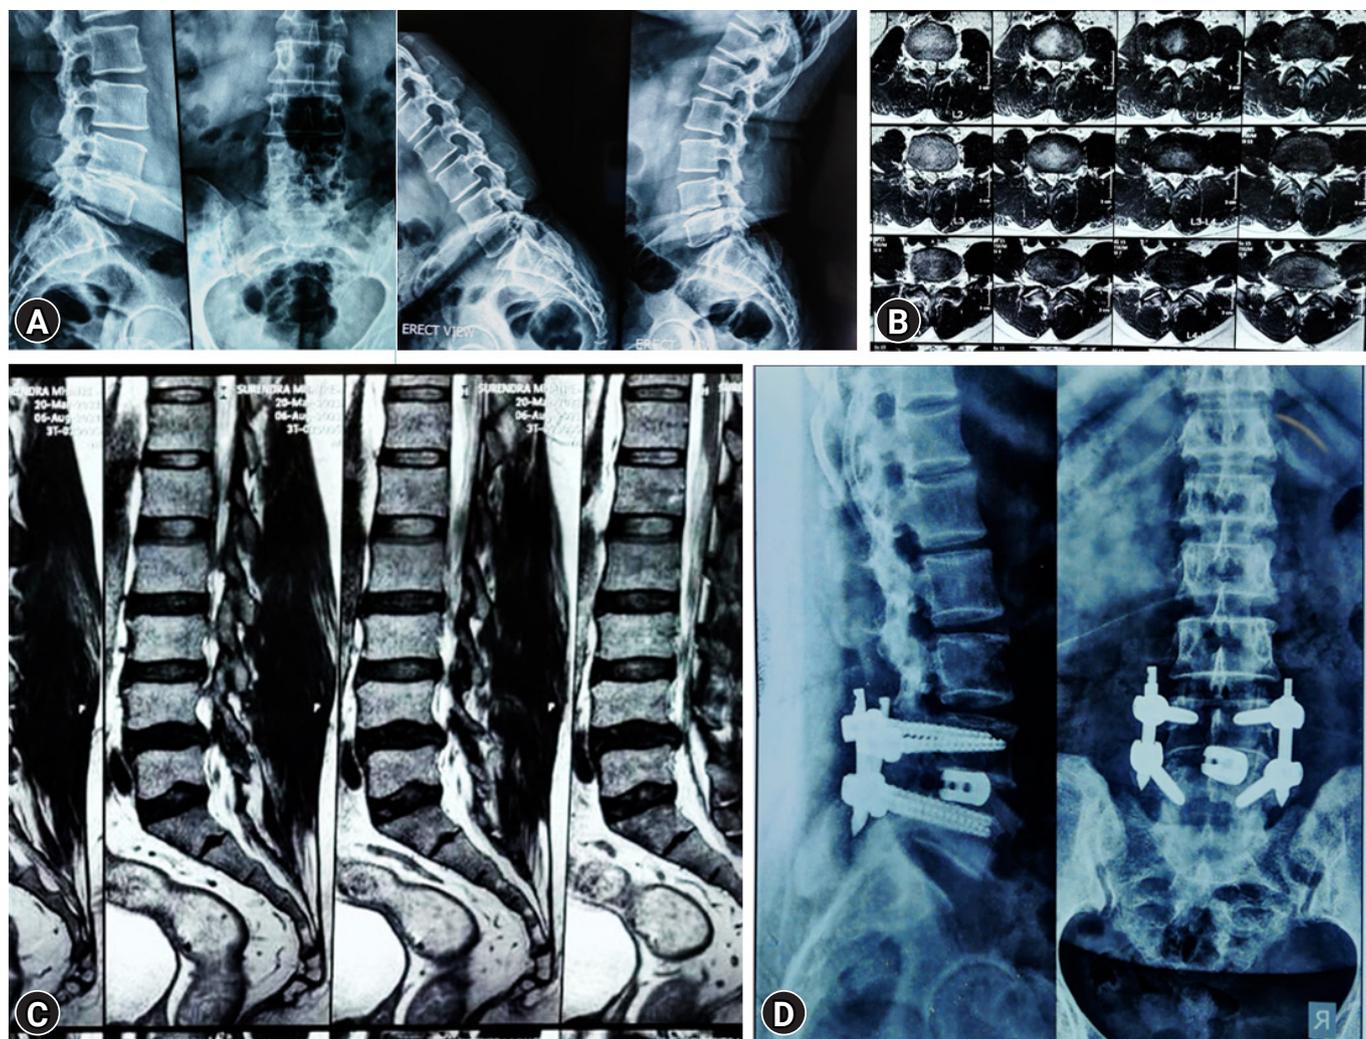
Index case. (A) Pre-operative plain radiographs. (B) Axial MR images. (C) Sagittal MR images. (D) Post-operative plain radiographs.
